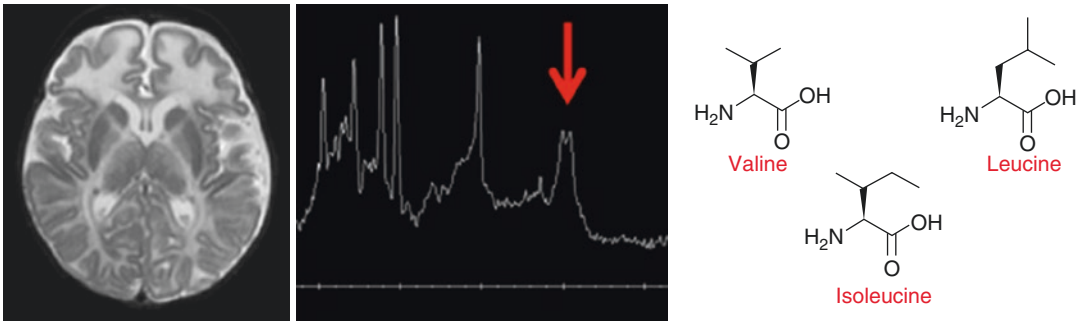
On the left, T₂-weighted MRI of a neonatal brain showing increased fluid signal in the frontal white matter. Short-TE ^1H MRS was performed, demonstrating resonances around 1 ppm corresponding to
